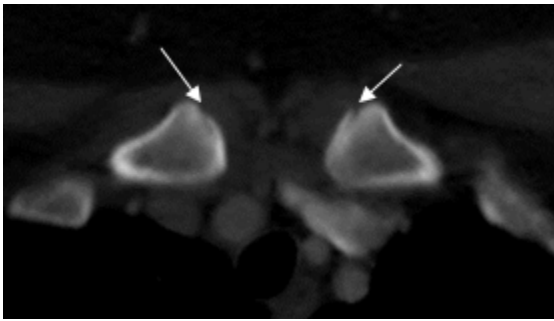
CT image of medial clavicles of a 20 year old female shows stage 3c ossification of bilateral epiphyseal cartilage (white arrows)
